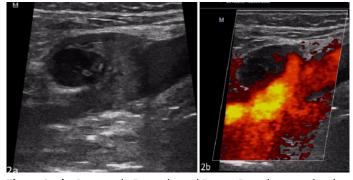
Gray scale B-mode and Power Doppler examination showing a saccular aneurysmatic dilatation in the middle portion of the popliteal vein with partially echogenic thrombotic material causing a filling defect within the lumen
